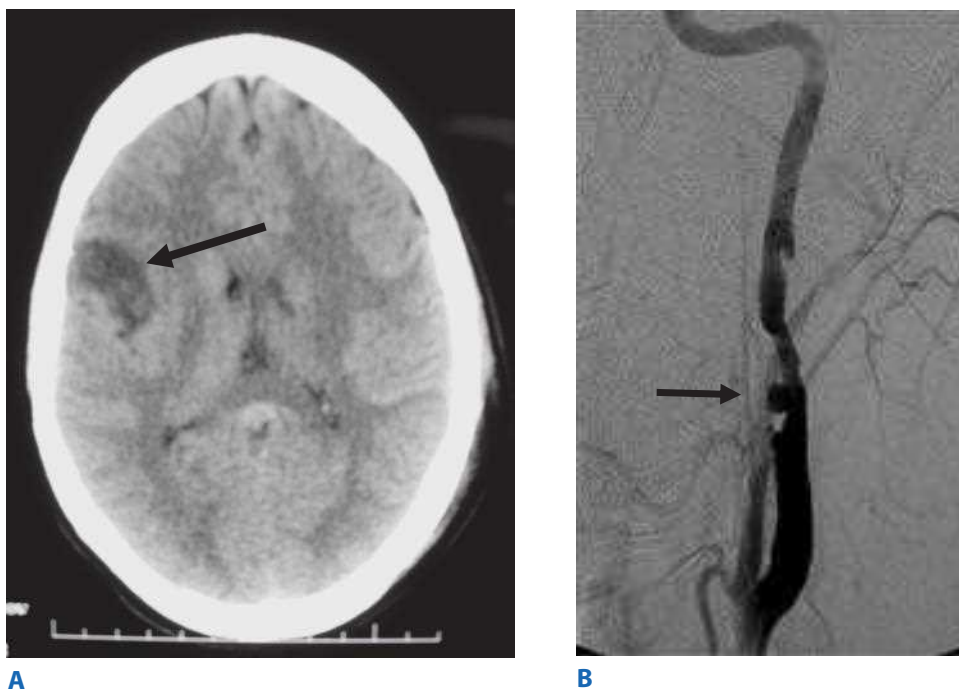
A. A right middle cerebral infarct noted on a computed tomographic scan of the head. Such a finding should prompt imaging to rule out an associated extracranial cerebrovascular injury. B. An internal carotid artery pseudoaneurysm documented by angiography.
